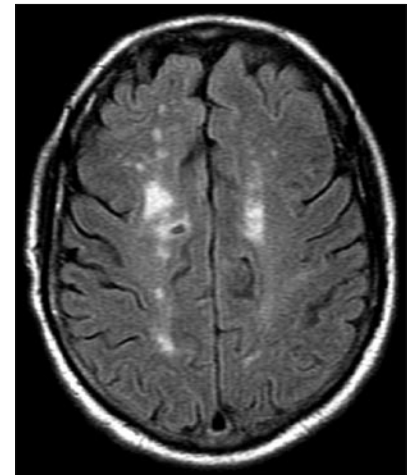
Axial FLAIR MR image reveals bilateral frontal lobe periventricular and subcortical white matter hyperintensity. A remote lacunar infarction is present in the right centrum semiovale.
